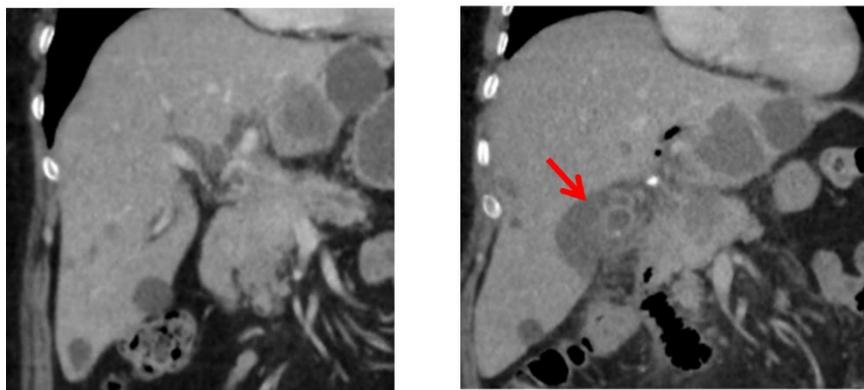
CT scan before (left) and after (right) ERCP showing biloma development around the gallbladder (highlighted)
